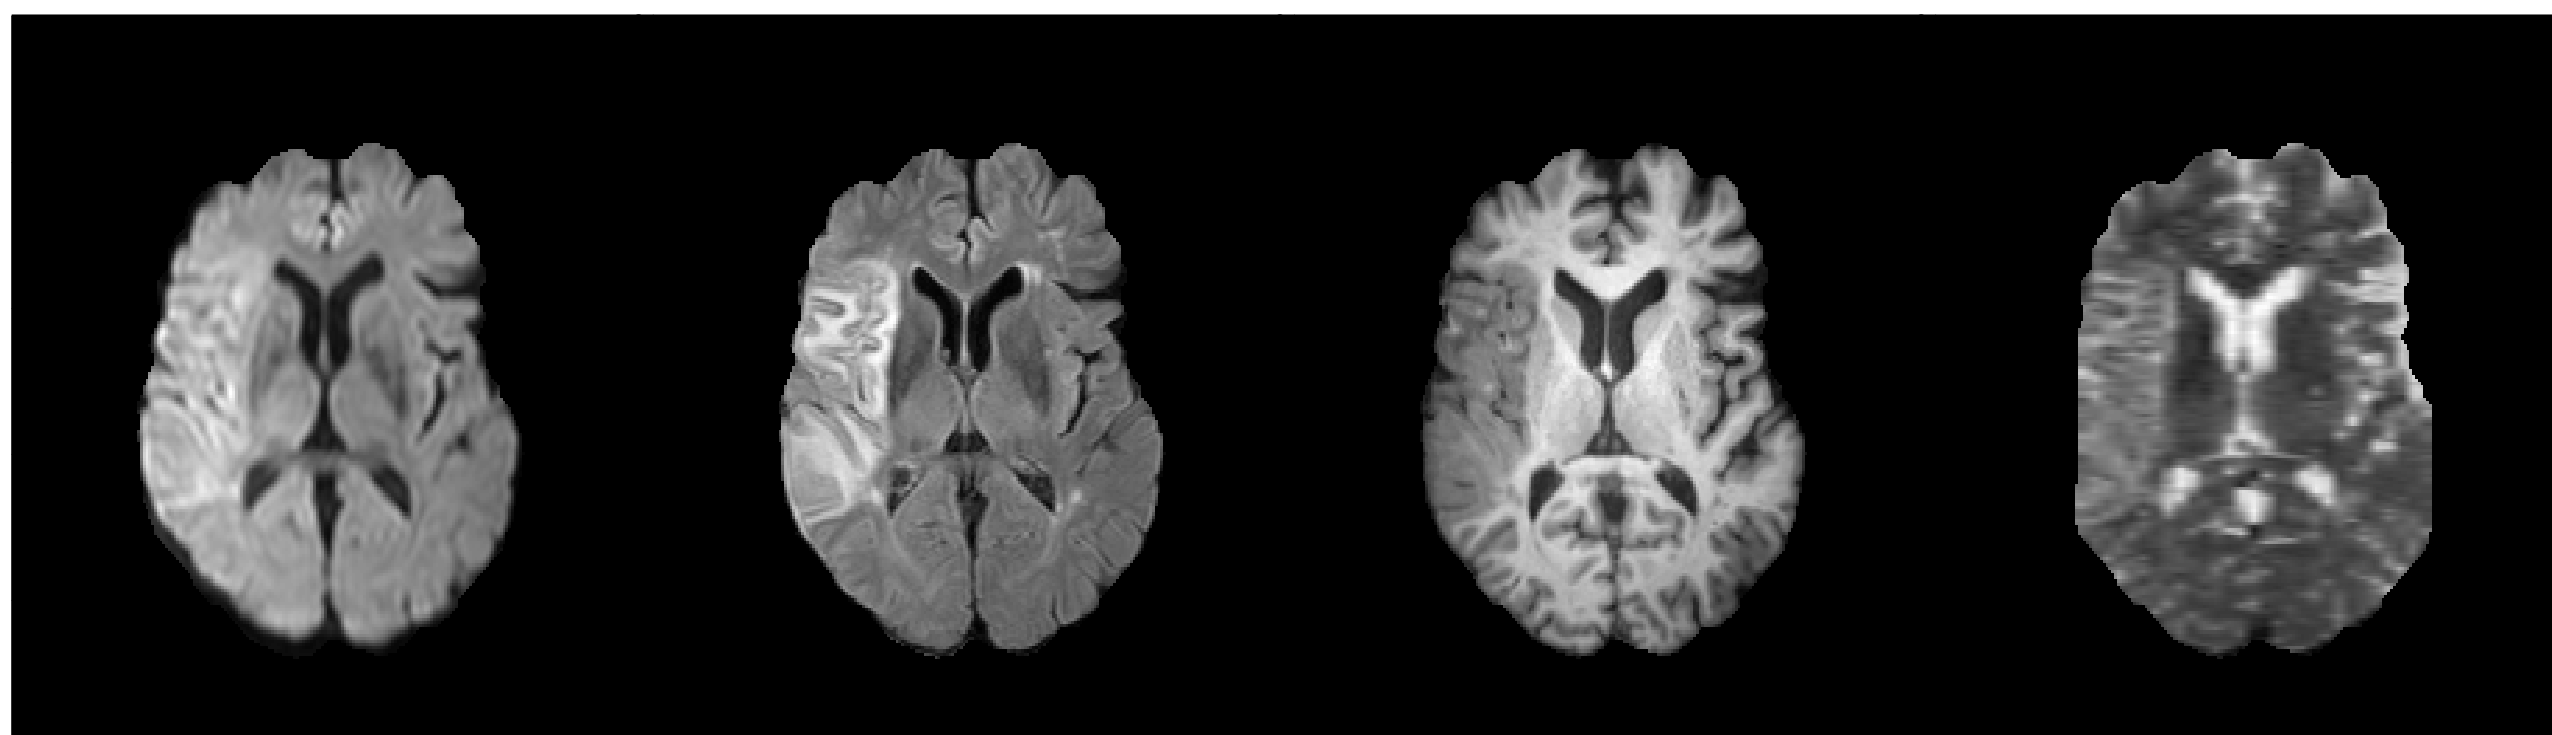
From left to right: DWI, FLAIR, T1w, and T2w images for subject 05, 2015 ISLES Challenge
